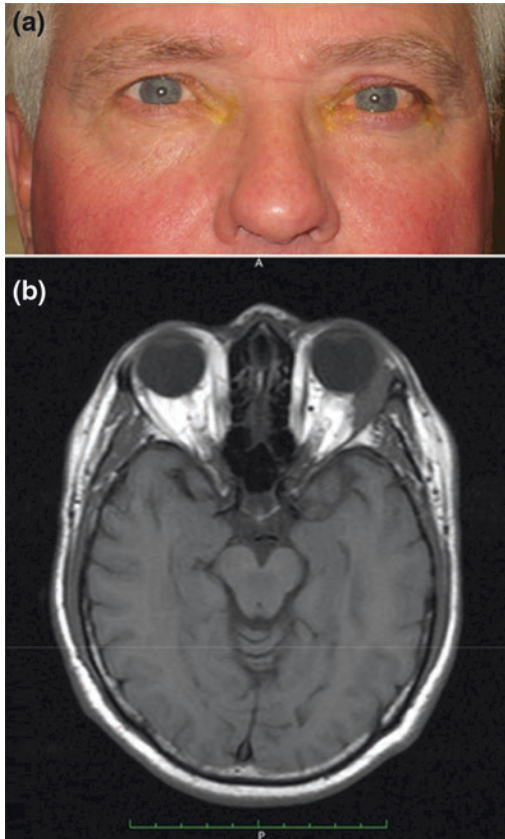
a Non-axial displacement of the globe inferonasally is secondary to the lacrimal gland tumor seen on the CT scan. b This malignant tumor, ductal adenocarcinoma of the lacrimal gland, presented chronically after 6 months of vague pressure and eventual hypesthesia over the lateral eyebrow
